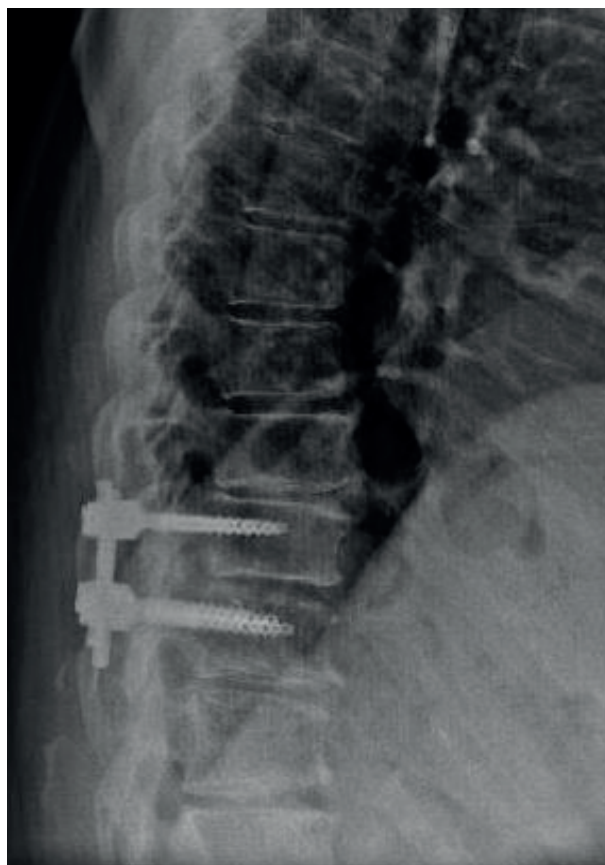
Post-operative X-Ray, where could be assessed the results of arthrodesis T10-T11.
